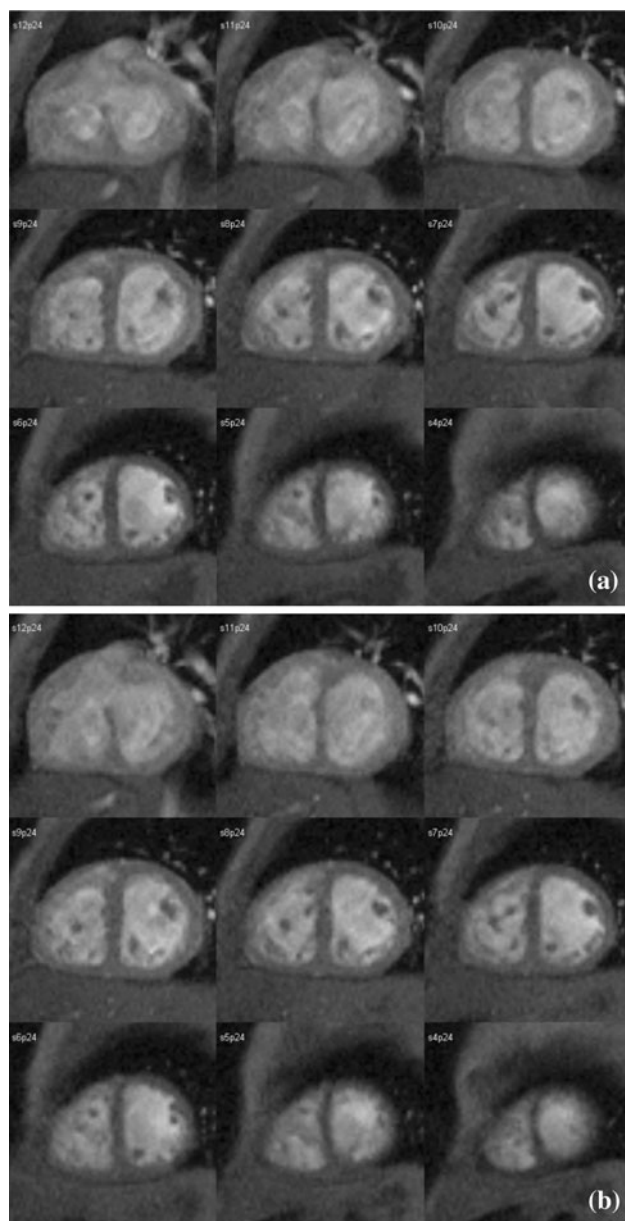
SSFP MRI obtained using a Siemens 1.5-T Symphony magnet with a conventional and b oscillatory ventilation
